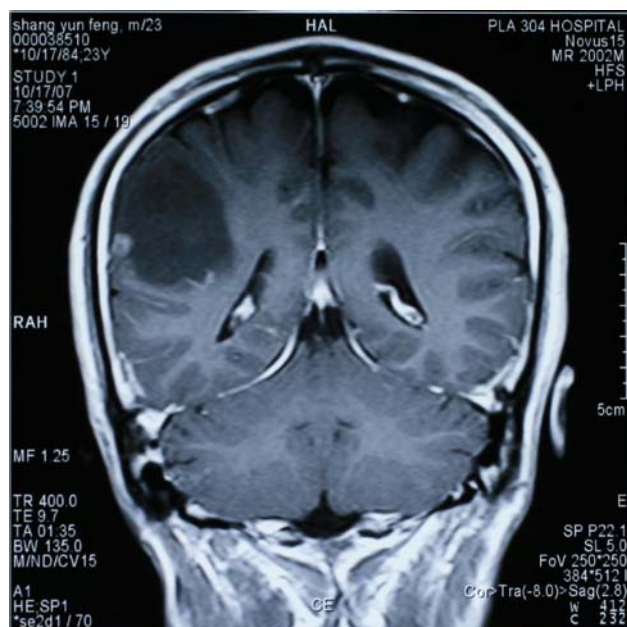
Gd-enhanced coronal T1-weighted MR images before first operation demonstrating a nodular-enhanced mass in the right parietofrontal region
